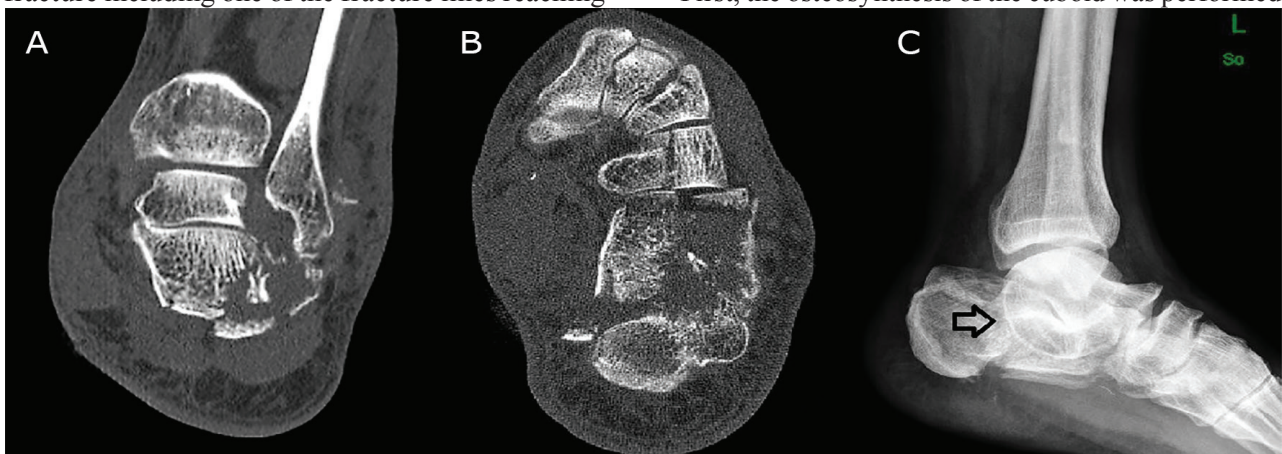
Axial computerized tomography (CT) scan depicting the fracture of the tip of the lateral malleolus (A); and a comminuted calcaneal fracture and a transverse fracture of the cuboid (B); The lateral ankle radiograph shows the calcaneal fracture with the talocalcaneal coalition including the “C-Sign” (arrow) (C).
